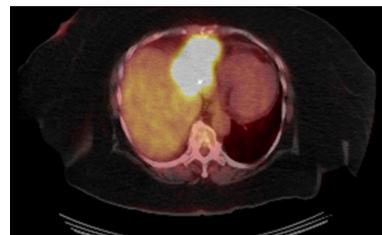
Cross section of PET/CT pre- treatment
